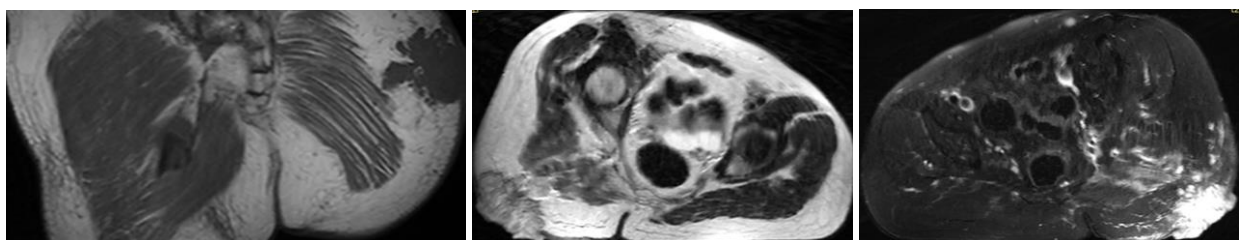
Coronal T1-weighted and T2-weighted sequences: soft tissue mass located above the aponeurosis in the subcutaneous tissues of the left gluteal region hypointense on T1 and hyperintense on T2
